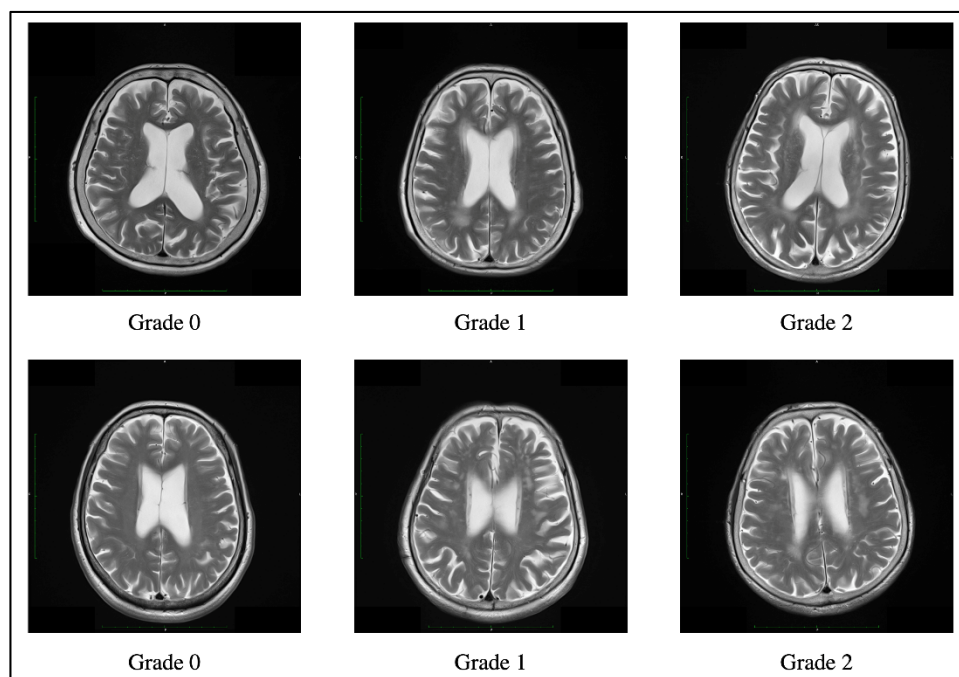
Example of a Fazekas scale score of 0, 1, and 2 periventricular hyperintensity (top) and deep white matter hyperintensity (bottom) on T2-weighted images.
